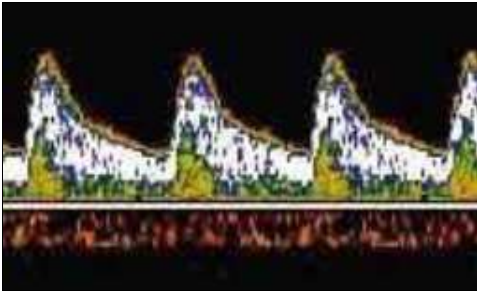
Normal impedance to flow in the umbilical arteries and umbilical vein in late 2nd and 3rd trimester with end diastolic flow (Doppler in Obstetrics by The Fetal Medicine Foundation, chapter 3)
